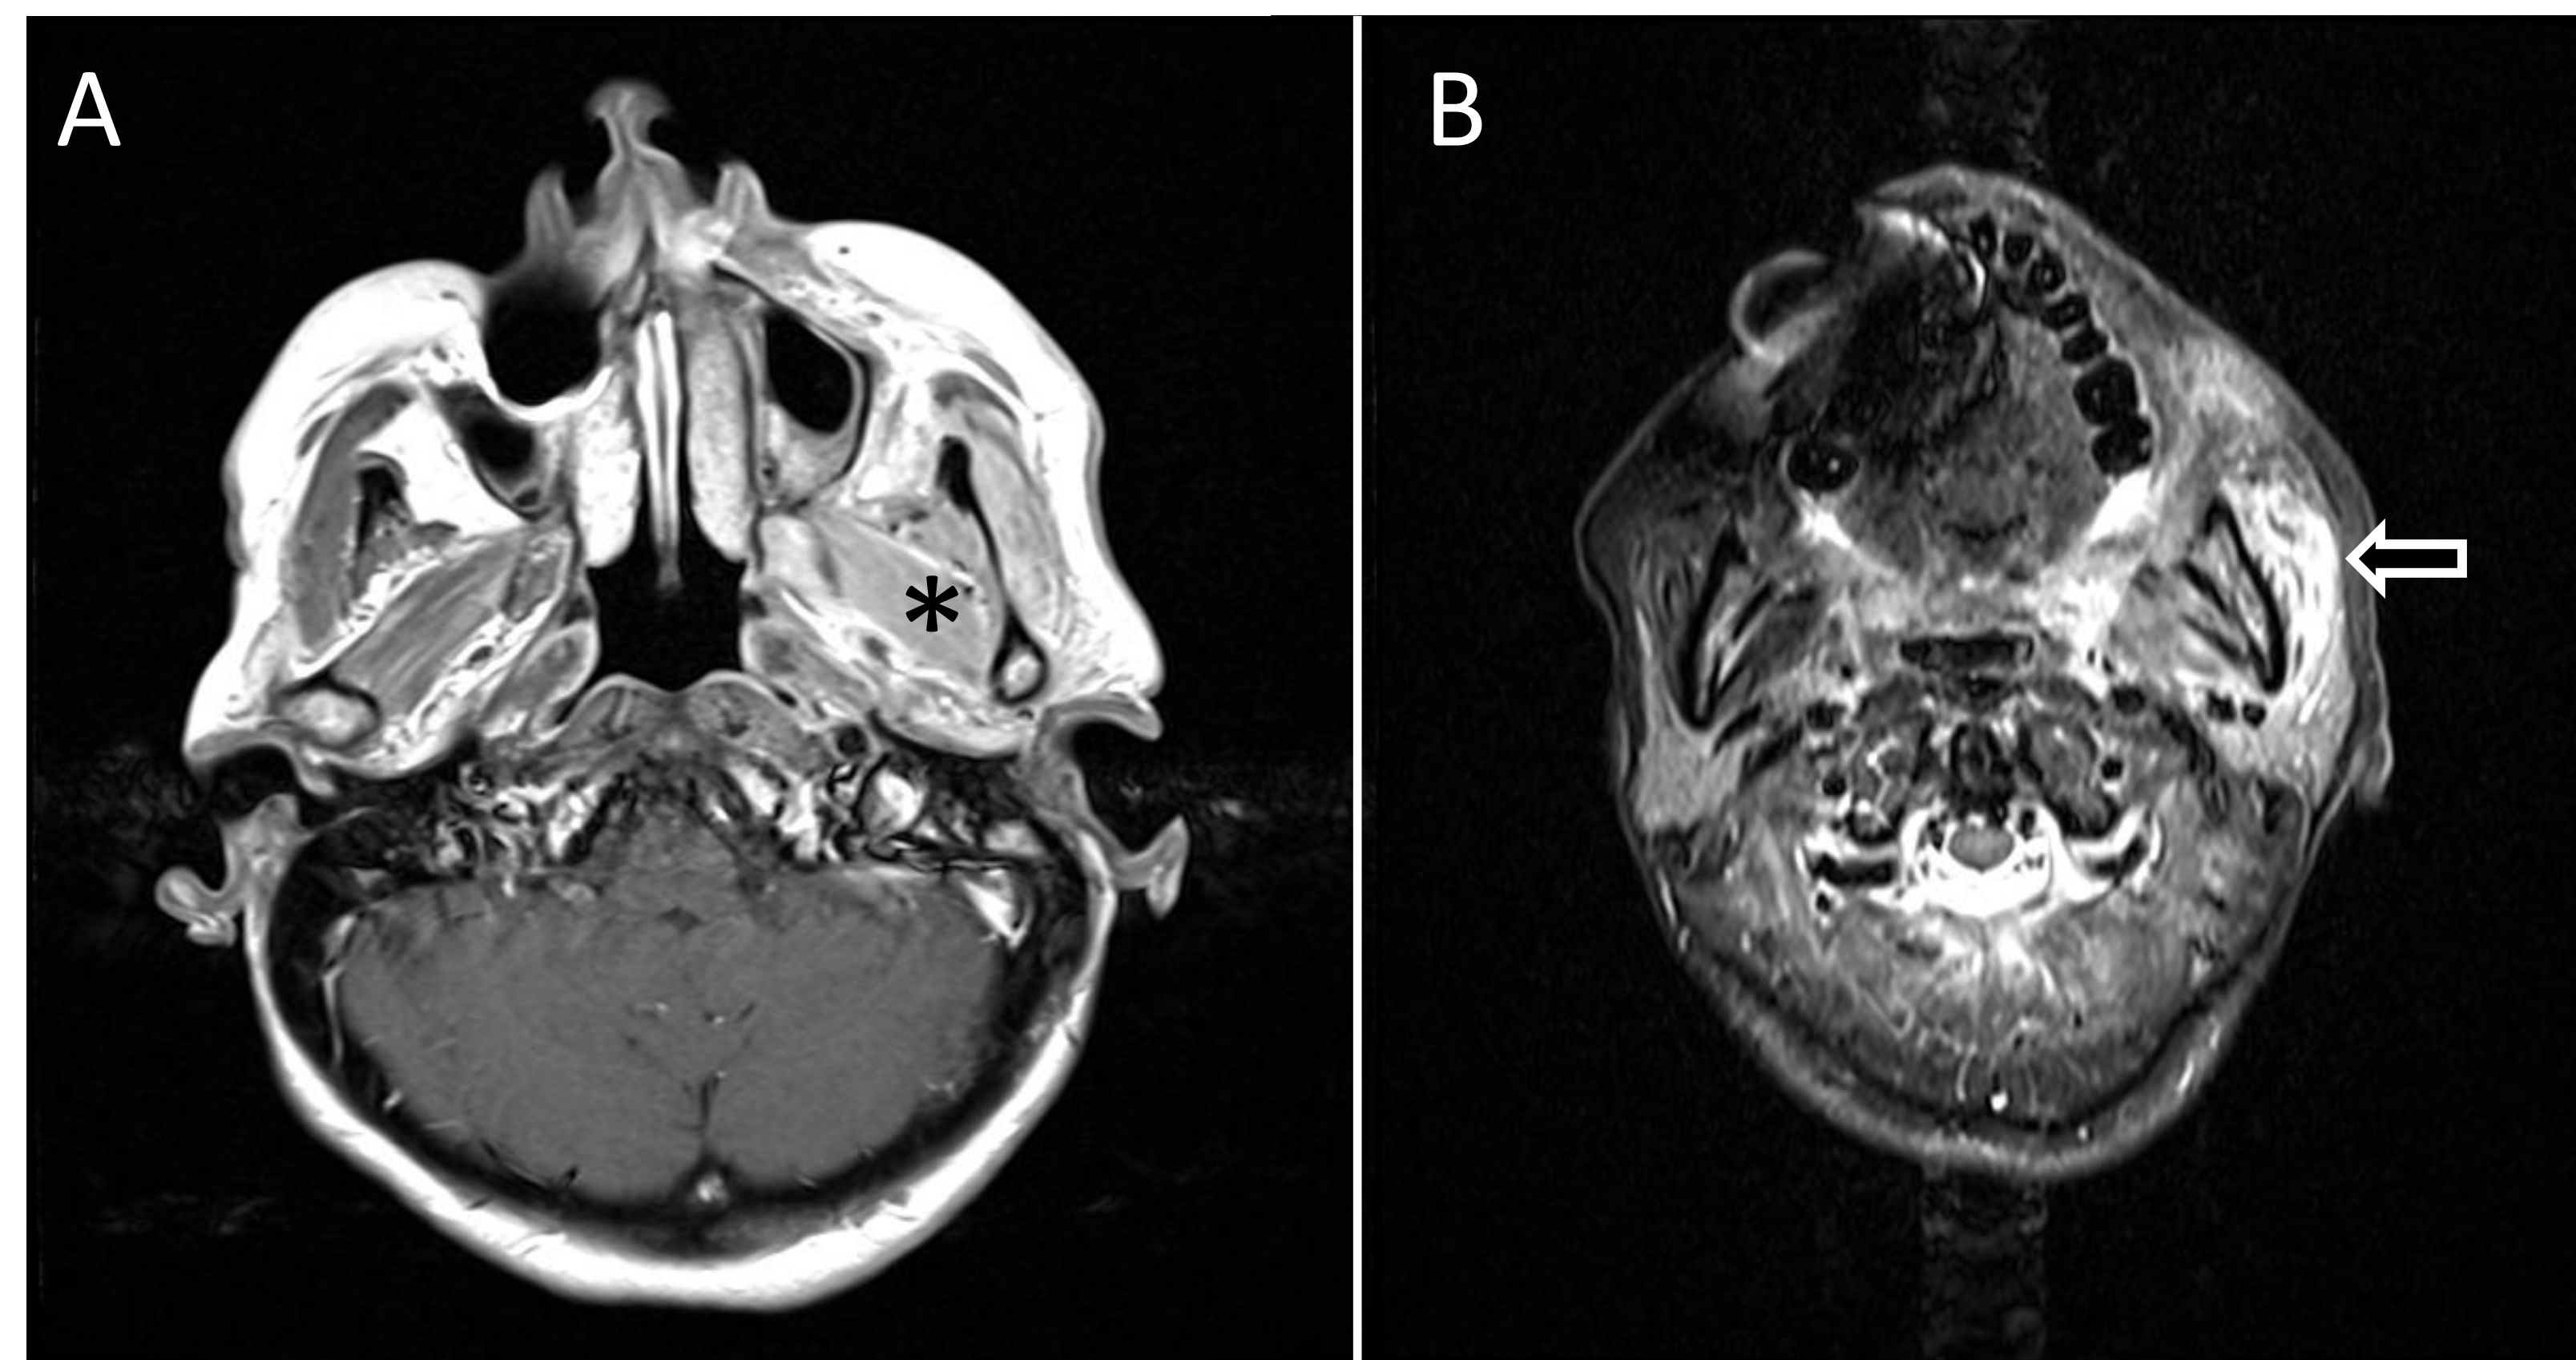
MRI demonstrating left lateral pterygoid (asterisk) and masseter (hollow arrow) muscle enhancement without any discrete lesion. A) T1-weighted post-contrast. B) T2-weighted STIR short-tau inversion recovery (STIR).
